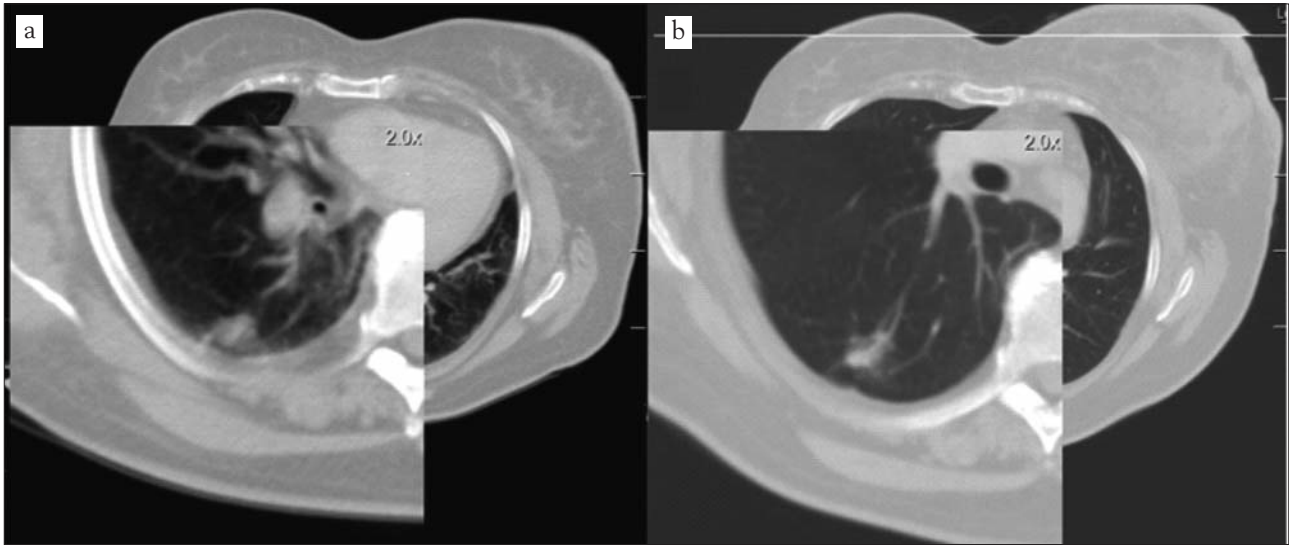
Transverse CT scans featuring the lung metastasis in (a) June 2014, then in (b) July 2015
